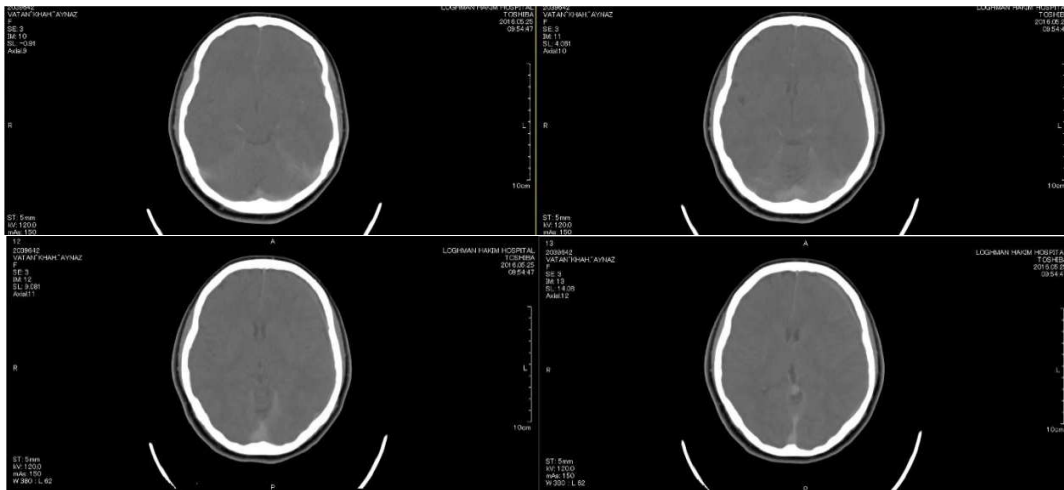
Brain CT scan showing small size subdural hematoma in occipital area
